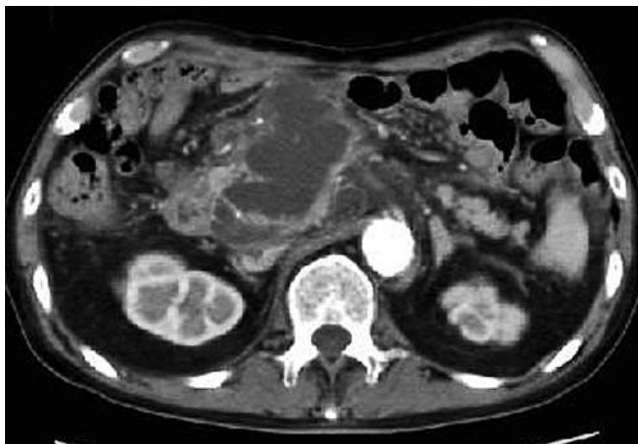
Computed tomography showed pancreatic abscess.
